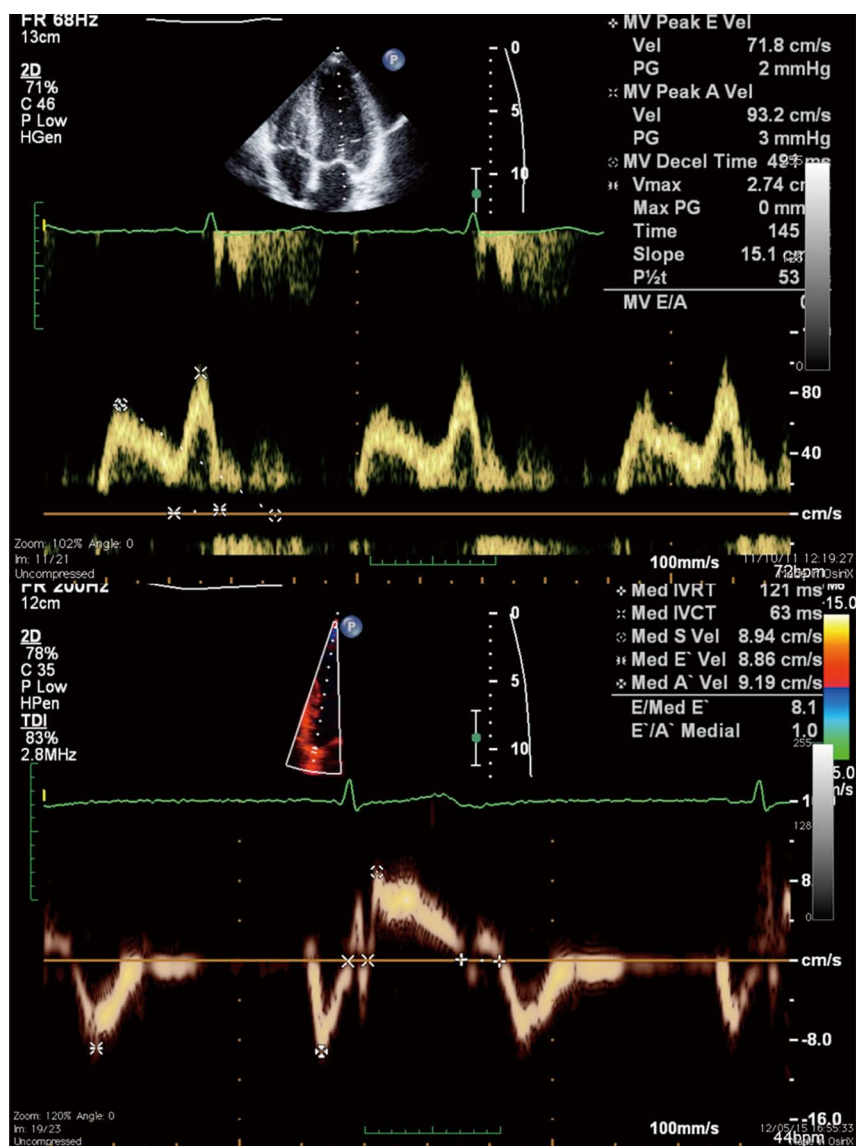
Mitral inflow velocities using pulsed-wave Doppler showing a impaired relaxation pattern (top), and tissue-Doppler derived mitral annulus velocities at the septal wall (bottom).
